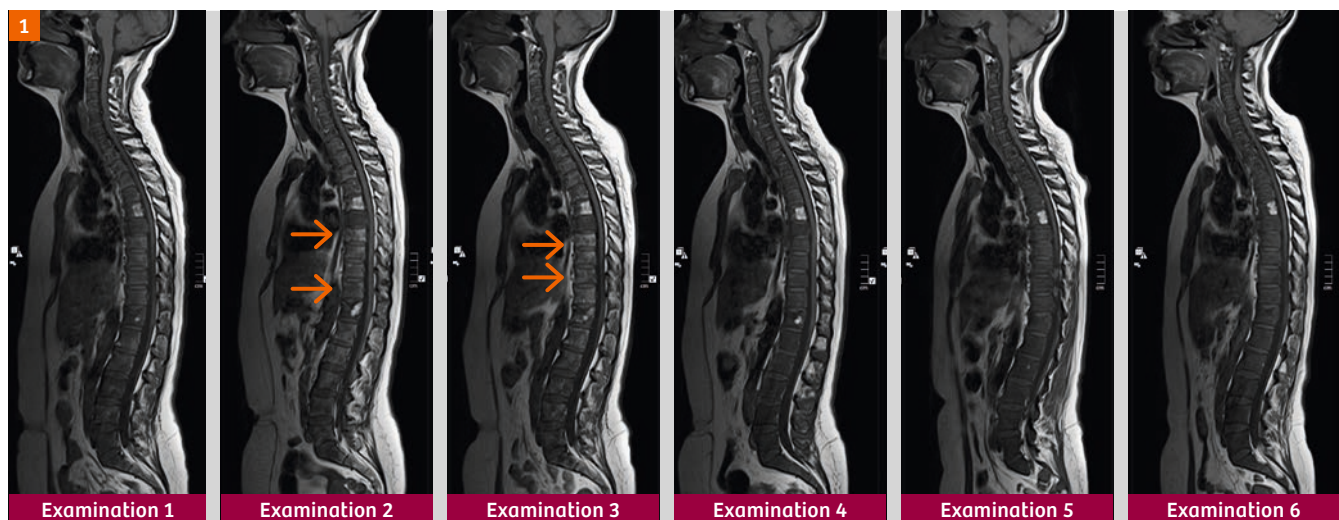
Whole-spine T1-weighted images show diffuse bone marrow infiltration with some return of bone marrow fat on examinations 2 and 3 (arrows) with first-line hormonal therapy. The bone marrow fat disappears at therapy relapse on examination 4 and no further T1w changes are detected after therapy change to second-line on examinations 5 and 6. There is a hemangioma in T6.
